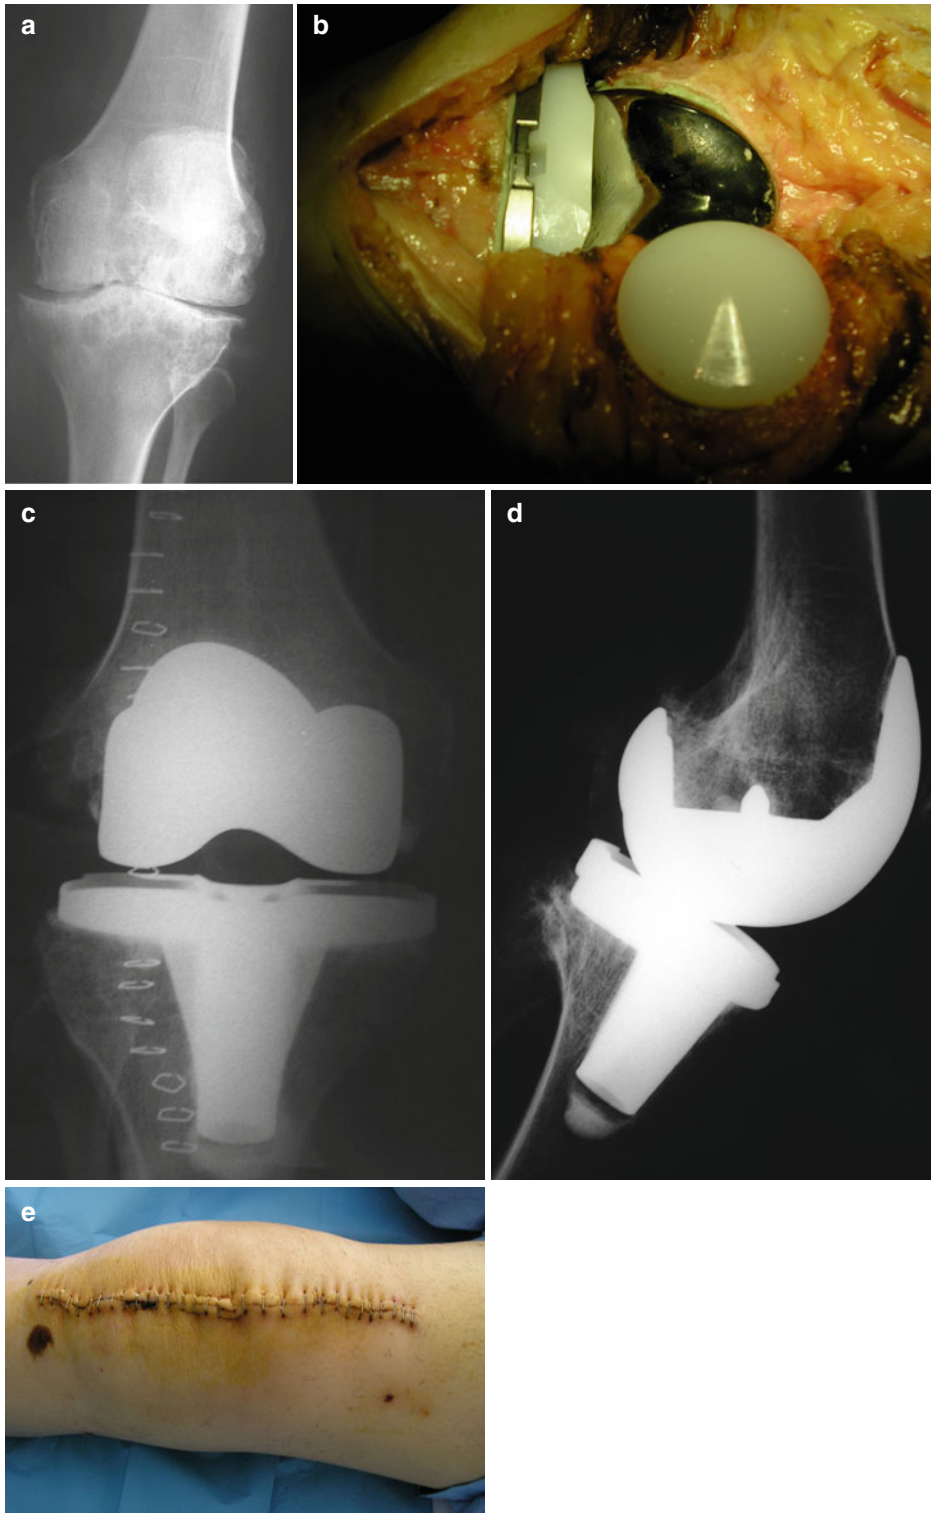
Total knee replacement (TKR) in a patient with hemophilia. Pharmacological thromboprophylaxis was not used: anteroposterior preoperative radiograph (a).
